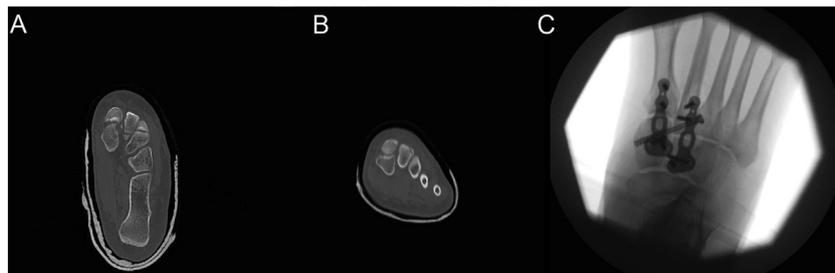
Pre-operative coronal and axial CT images demonstrating a medial split-depression fracture of the first metatarsal base in conjunction with clear avulsion of the Lisfranc ligament (Type A). Intra-operative fluoroscopic images show restoration of the midfoot anatomy with lagged screw fixation addressing the avulsed Lisfranc ligament and bridge plating across the 1 & 2 TMTJs to restore stability of these joints.
